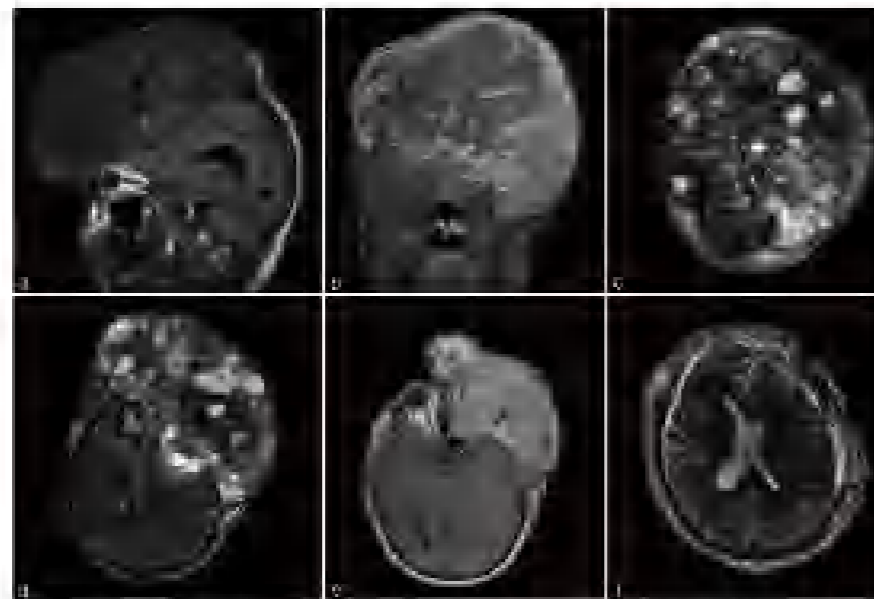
Preoperative radiographic images of disfiguring osteosarcoma tumor mass (Case 1). (A) Sagittal view, T1-weighted MRI showing disfiguring tumor (obstructing the left eye). (B) Postcontrast MRI, CT (ax) and (C) Axial view, T2-weighted MRI showing well-defined enhancing nodules within the mass. (D) Axial view, CT (D). Axial view, T1-weighted MRI showing displacement of brain parenchyma.
